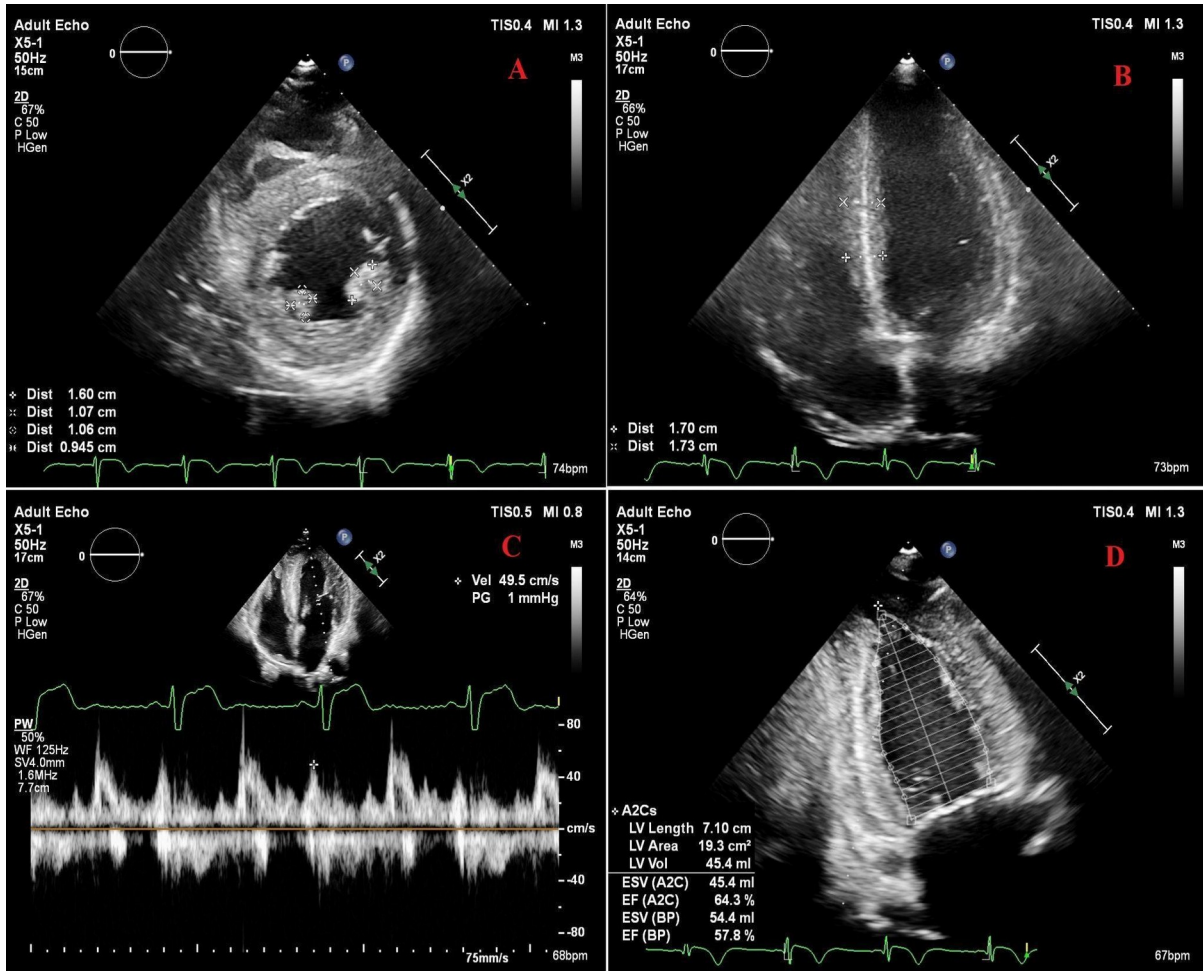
Transthoracic echocardiography: A. Parasternal short axis, thickening of the papillary muscles; B. Apical 4 chamber view, increased thickness and brightness of IVS myocardium; C. Pulse doppler imaging: mitral flow; D. Apical 2-chamber view, assessment of LV ejection fraction, concentric LV hypertrophy; IVS — interventricular septum; LV — left ventricular
